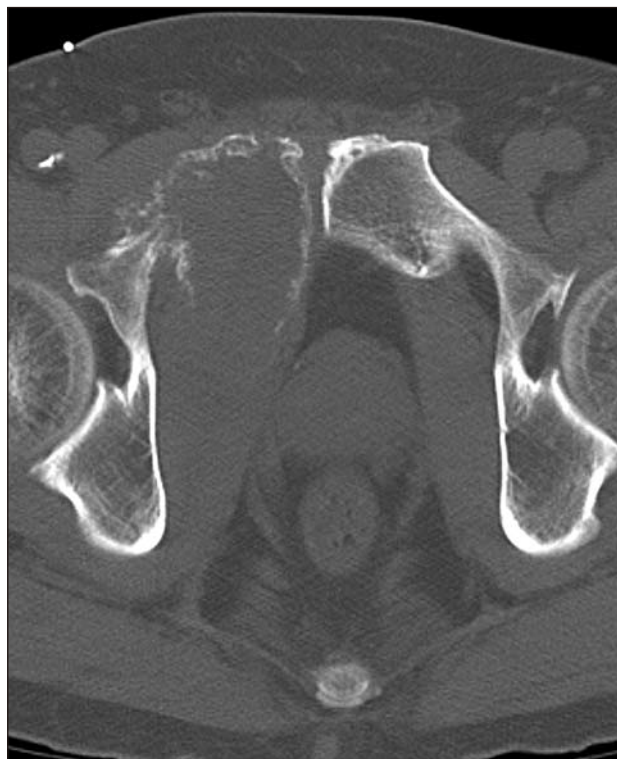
Computed tomography image showing the expansile osteolytic bone lesion in the right superior pubic ramus.
